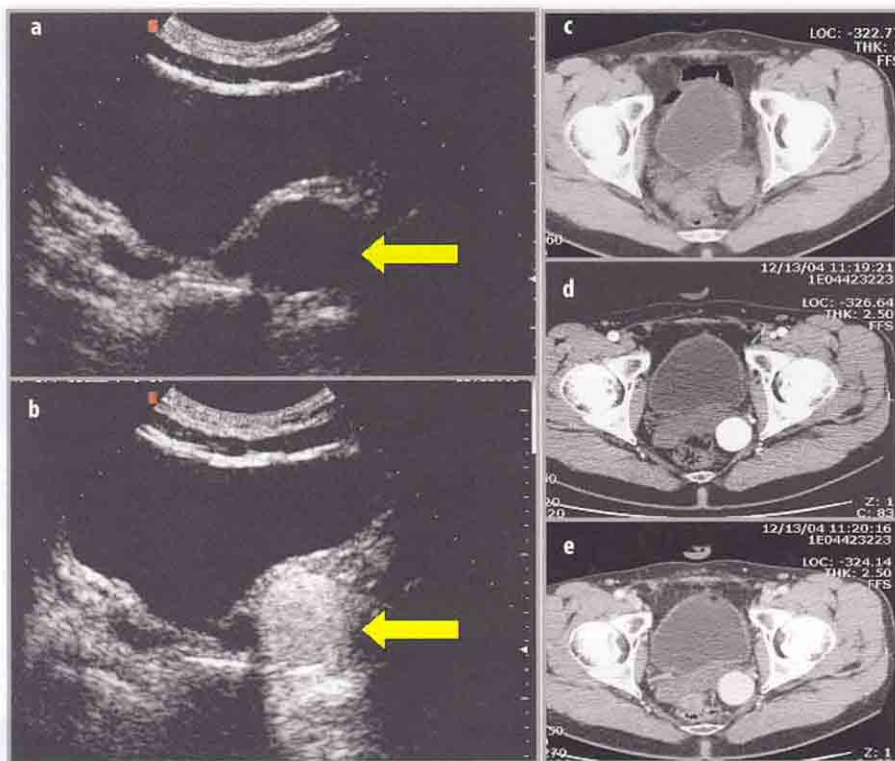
Hypogastric aneurysm. a Transversal scan, B-mode. A small anechoic rounded lesion (yellow arrow) is detected posteriorly and left laterally to the urinary bladder. b Transversal scans, CEUS. After contrast administration, a homogeneous enhancement inside the rounded image is already evident in arterial phase (yellow arrow). c-e Angio-CT, transversal plane. In baseline scan (c) the rounded image is confirmed behind the bladder; it homogeneously enhances in arterial phase (d) and more poorly in late vascular phases (e)
